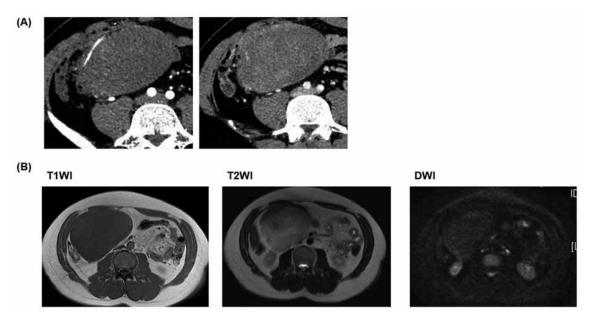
(A) Abdominal CT shows a large, 12-cm mass. The artery is compressed by tumor in artery phase. Enhancement is very weak and homogeneous in venous phase
